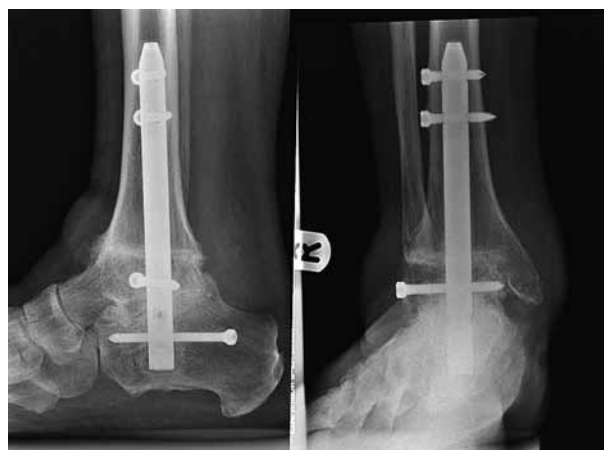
Post-operative radiographs of the patient shown in figure 3a. The patient had tibiototal calcaneal arthrodesis with intramedullary nail. The figure shows neutral alignment and bony union at 6 months after the surgery.
